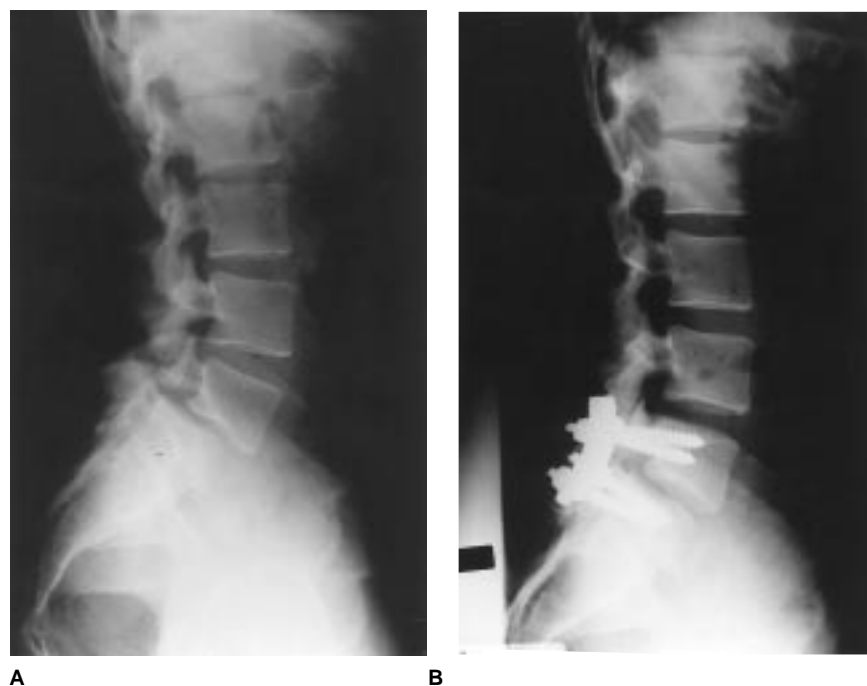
Plain lateral radiograph (A) of a 24-year-old man with a 2-year history of low back pain and a 1-year history of worsening leg pain and paresthesias. Low-grade isthmic spondylolisthesis is seen at L5-S1. B, The patient underwent resection of the loose arch at L5, with bilateral foraminotomies and decompression of the L5 nerve roots and posterolateral fusion with pedicle-screw instrumentation at L5-S1.
